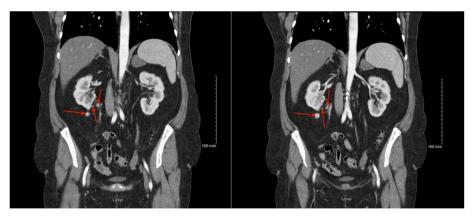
CT imaging showing multiple small recurrences of RCC in the retroperitoneum.
